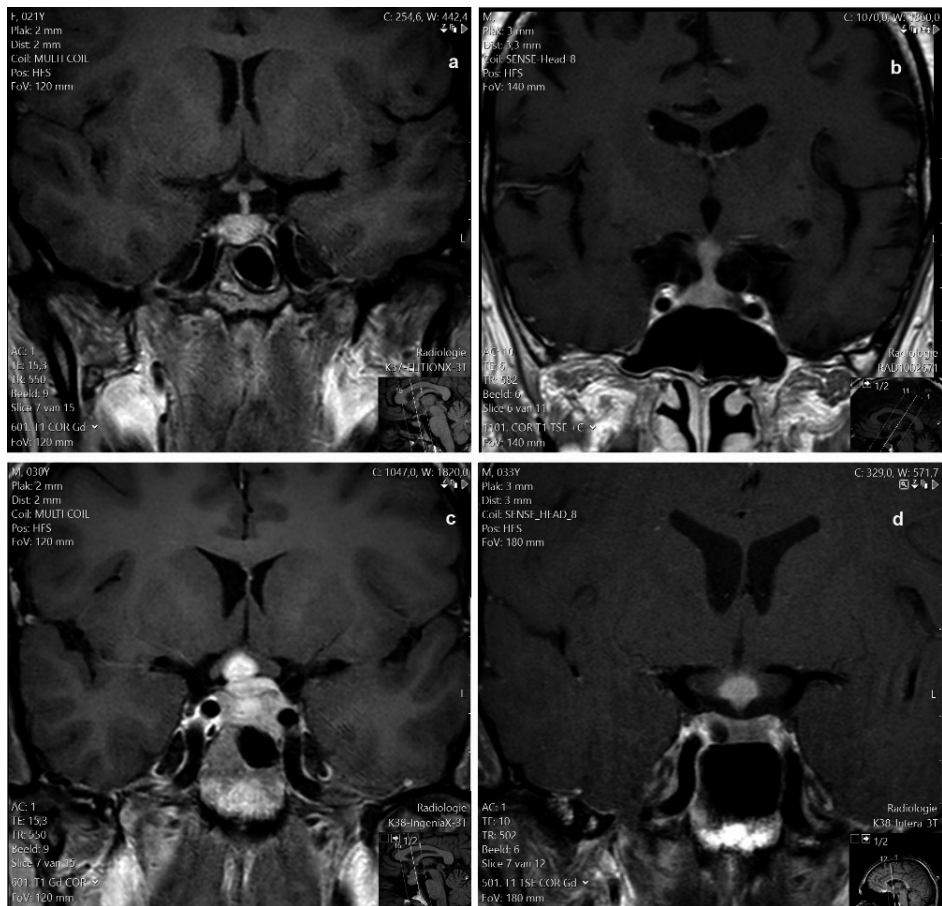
MRI images of 4 types of hypophysitis, all showing typical pituitary stalk thickening. a: lymphocytic hypophysitis, b: IgG4-related hypophysitis, c: granulomatous hypophysitis in the context of neurosarcoidosis, d: Langerhans cell histiocytosis (this image also shows a small cystic pituitary adenoma)
